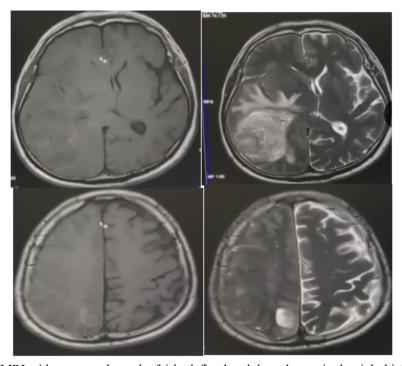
Cranial MRI with contrast showed a fairly defined nodule and mass in the right high parietal lobe and right temporo-parietal-occipital lobes exhibiting on T1 a hypo to isointense signal, interspersed with hyperintense signals and on T2 showed heterogenous hyperintense signal abnormalities with respective measurement of 2.0x1.4x2.1cm and 5.2x 4.5x 5.0cm.
